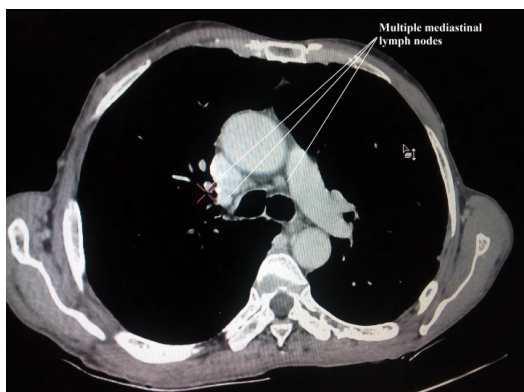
CT showed Multiple well defined enhancing nodes in mediastinal region.
